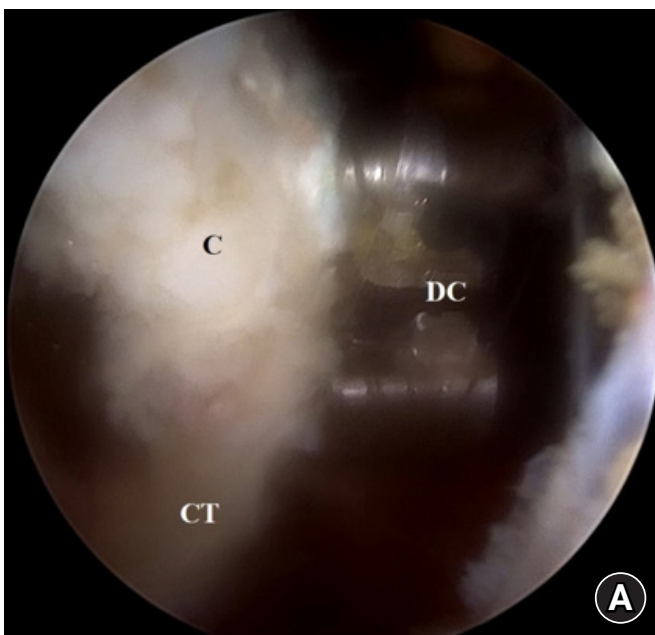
The double cannula connected to the osteotomized coracoid process (viewing portal: inferior, working portal: medial, right shoulder). (A) The osteotomized coracoid process is connected by the double cannula for fixation to the anterior glenoid. (B) Extra-corporeal view of the double cannula. The coracoid process can be easily controlled using a double cannula inserted through the medial portal. C: coracoid process, DC: double cannula, CT: conjoined tendon.
